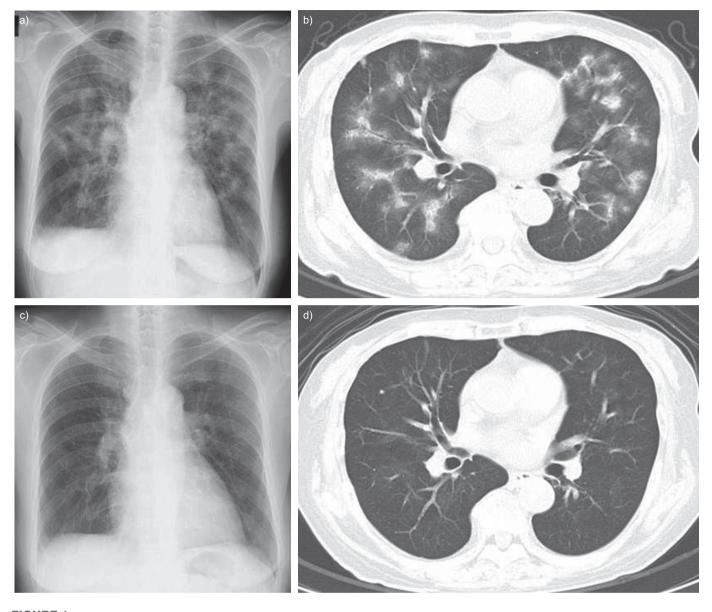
a) Chest radiograph showing patchy airspace infiltrates in both lungs. b) Chest computed tomography (CT) image showing bilateral ground-glass opacities and patchy infiltration in predominantly peribronchial and subpleural distribution. c) Chest radiograph and d) CT after 4 weeks of follow-up showing almost complete resolution of the bilateral opacities.
